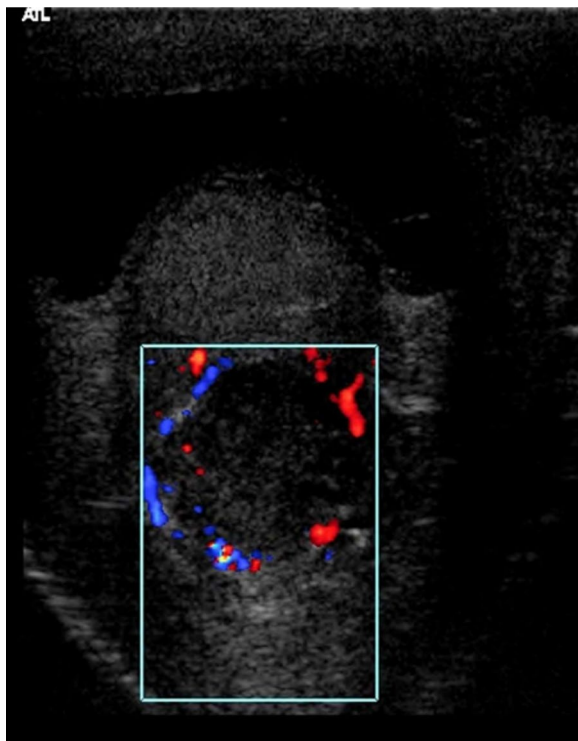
Color Doppler ultrasound of the testicles shows the hypovascular nature of the lesion (lesion inside the rectangle)
